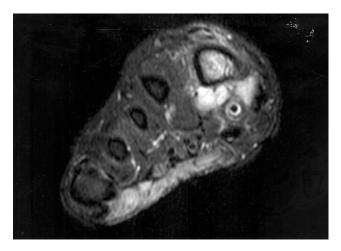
T2-weighted axial foot MRI depicting foreign body as a target appearance similar to flexor tendon.
